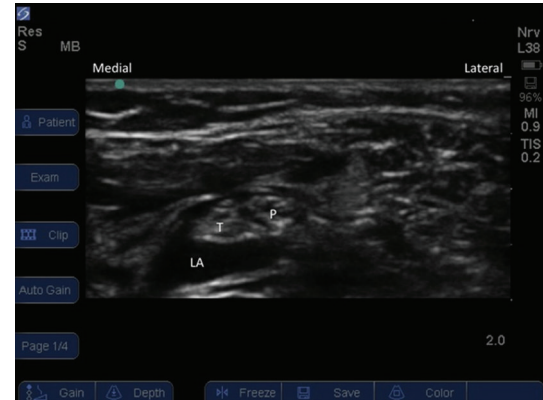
Ultrasound view of the sciatic nerve at the popliteal level. Probe positioned transverse, approximately 3 cm superior to the popliteal crease. LA: local anaesthetic, T: tibial nerve, and common peroneal nerve.
